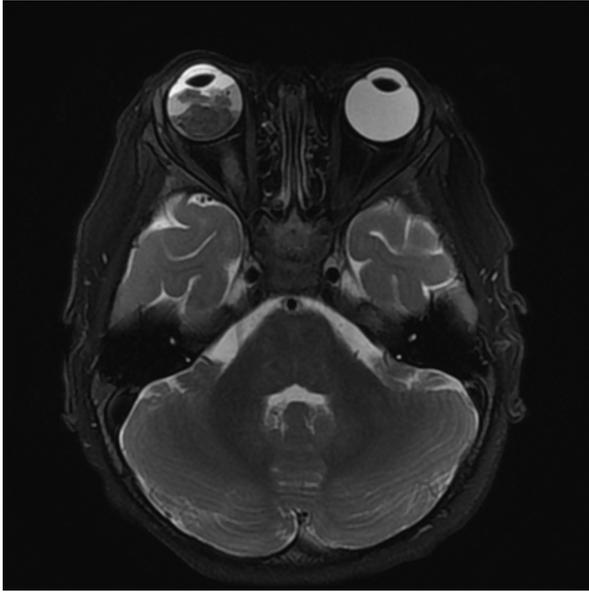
Magnetic resonance imaging orbits T2 FS demonstrates a heterogenous enhancing and calcified right intraocular mass with serous retinal detachment. The right optic nerve is involved extending to the prechiasmatic segment. There is evidence of choroidal invasion with scleral thinning and suspected involved of the right anterior chamber.
